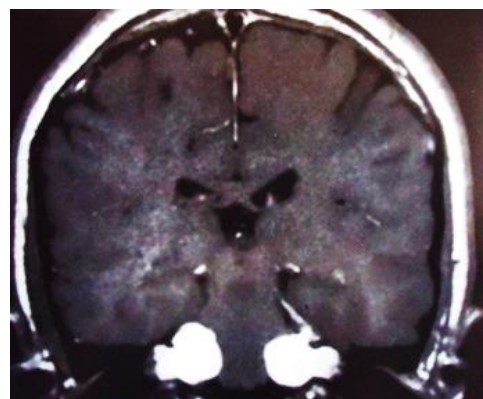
MRI image bilateral vestibular neuroma
